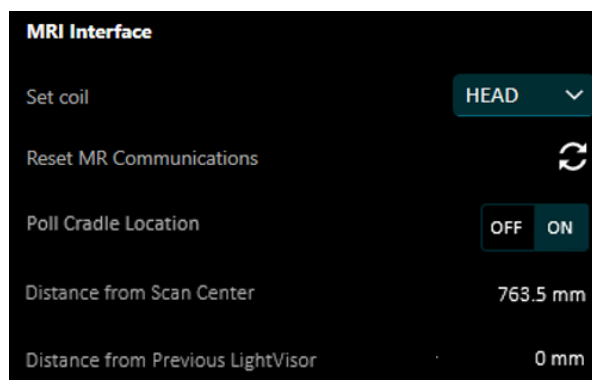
MRI Interface Section
